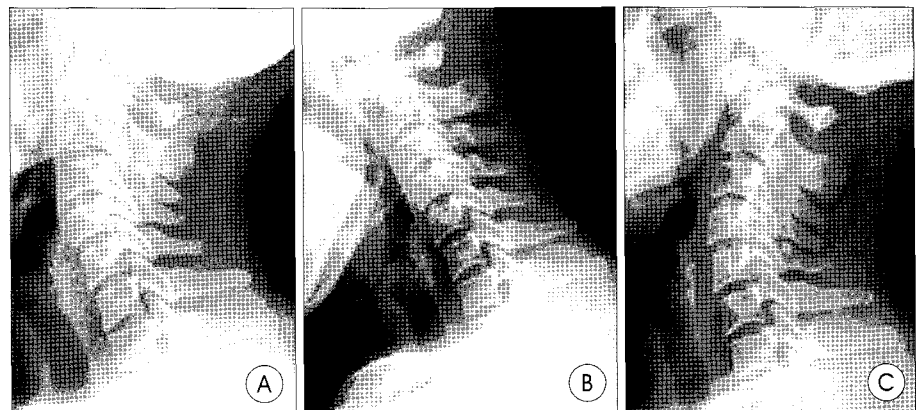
Plain radiographs of the cervical spine indicating os odontoideum. Flexion (B) and extension (C) lateral radiographs of the cervical spine revealing atlantoaxial instability.
